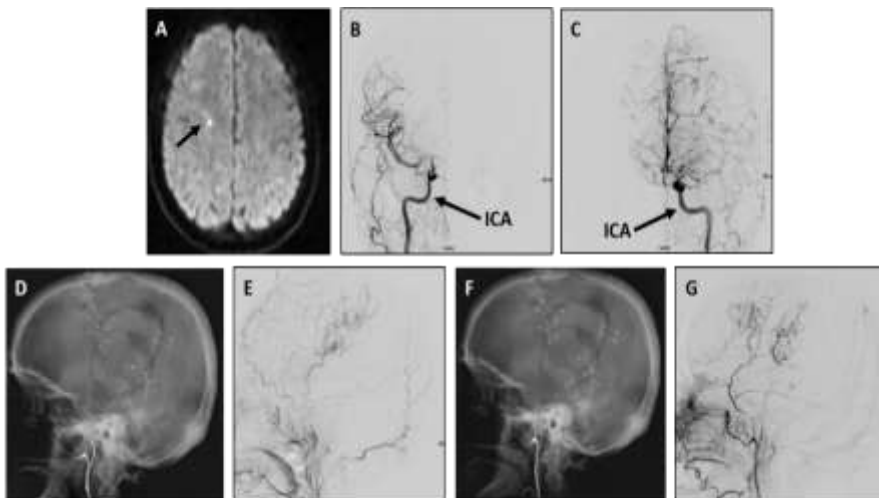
Diffusion-weighted MRI (A) shows small punctate infarcts along the ACA-MCA watershed (arrow). Right (B) and left (C) internal carotid artery injections on AP view demonstrate bilateral moyamoya. The patient underwent successful indirect bypass via the superficial temporal artery and middle meningeal artery with robust collateralization seen on the right [(D) unsubtracted and (E) subtracted] and left [(F) unsubtracted and (G) subtracted].
